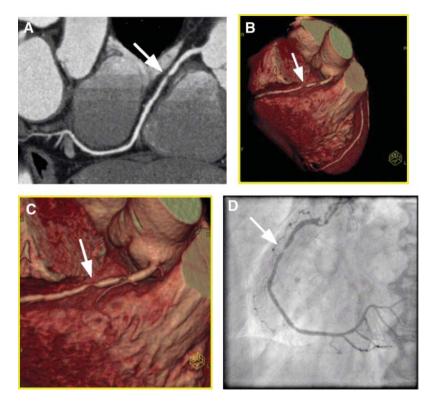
Stenosis of right coronary artery (arrows). A: Two-dimensional curved multiplanar reconstruction. B, C: Three-dimensional reconstruction of multiple-row detector helical computed tomography. D: Invasive coronary angiography. Reproduced with permission from Achenbach: Cath vs CTA. J. Nucl. Cardiol. 2005; 12: 703.
